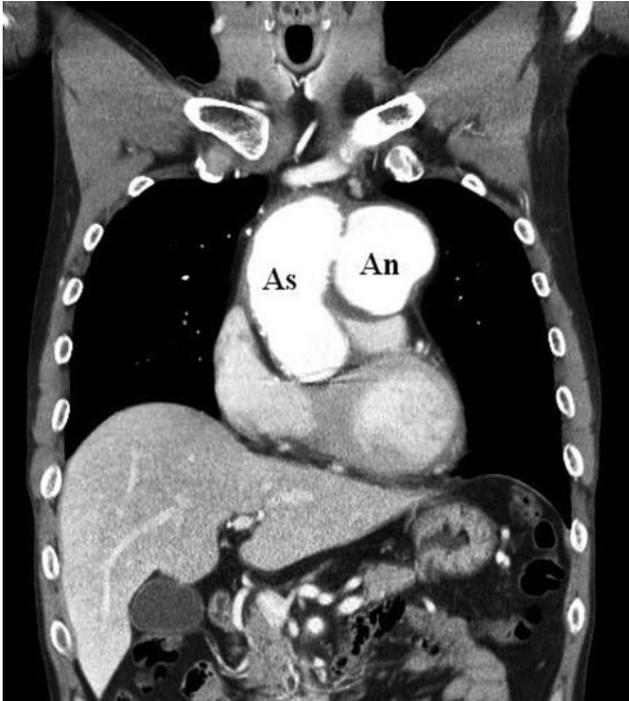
Chest computed tomography with contrast showed a huge (106 mm) ascending aortic aneurysm. As indicates ascending aorta; An, aneurysm.
